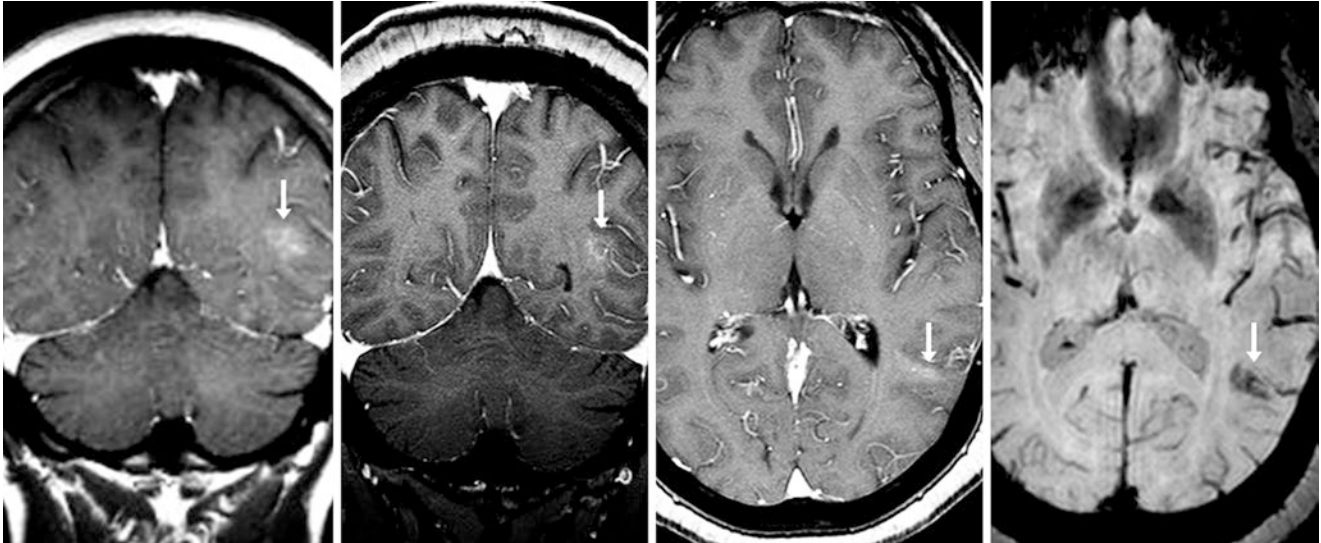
A 50 year old with chronic headaches underwent an otherwise negative 1.5T brain MRI that depicted mild enhancement within the posterior left temporal white matter (*arrows*) on postcontrast SE T1WI (*left*). Over 10 years later, this was unchanged on coronal (*left*
